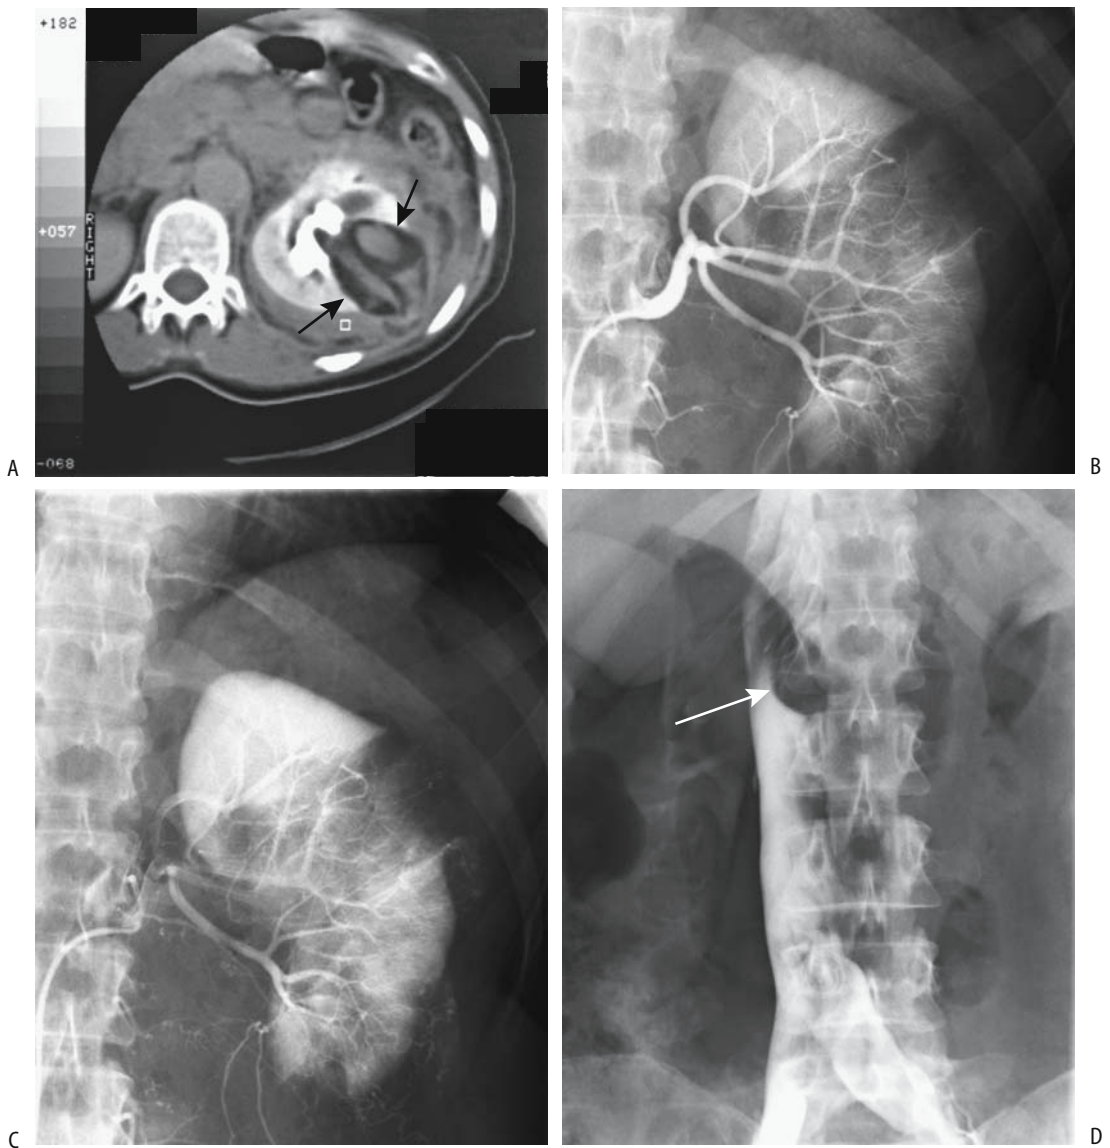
Angiomyolipoma with a retroperitoneal bleed. A: CT reveals a fat-containing left renal tumor (arrows). Arterial-phase (B) and delayed-phase (C) arteriography also identify the tumor but did not detect a site of bleeding. D: An inferior vena cavagram study reveals caval compression from the left side by the extensive retroperitoneal bleeding (arrow). (Courtesy of Oscar Gutierrez, M.D., University of Chile, Santiago, Chile.)
